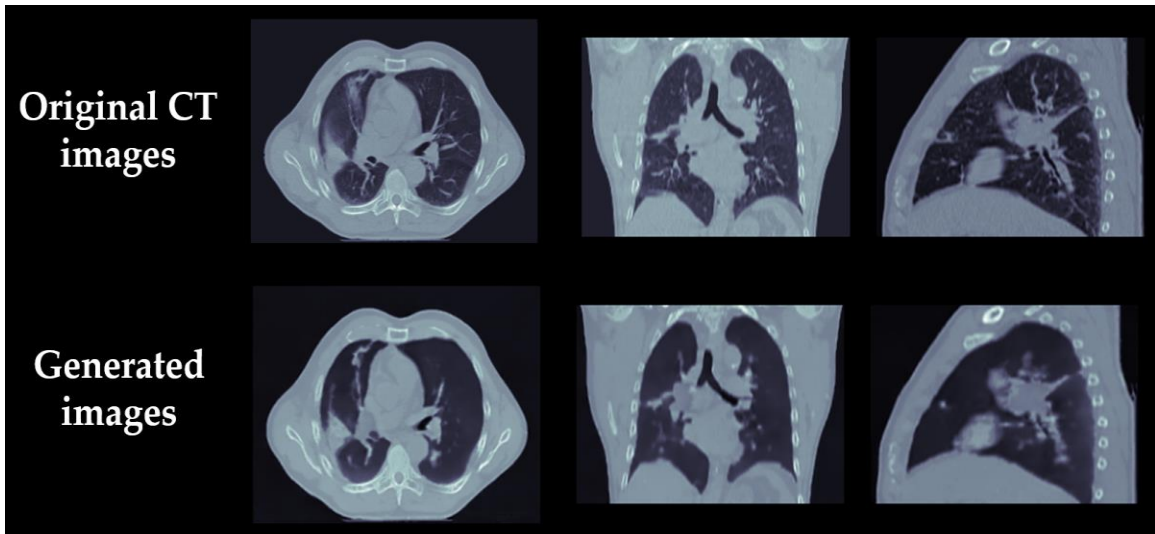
Original CT image versus generated image (left: transverse plane, middle: coronal plane, right: sagittal plane).
